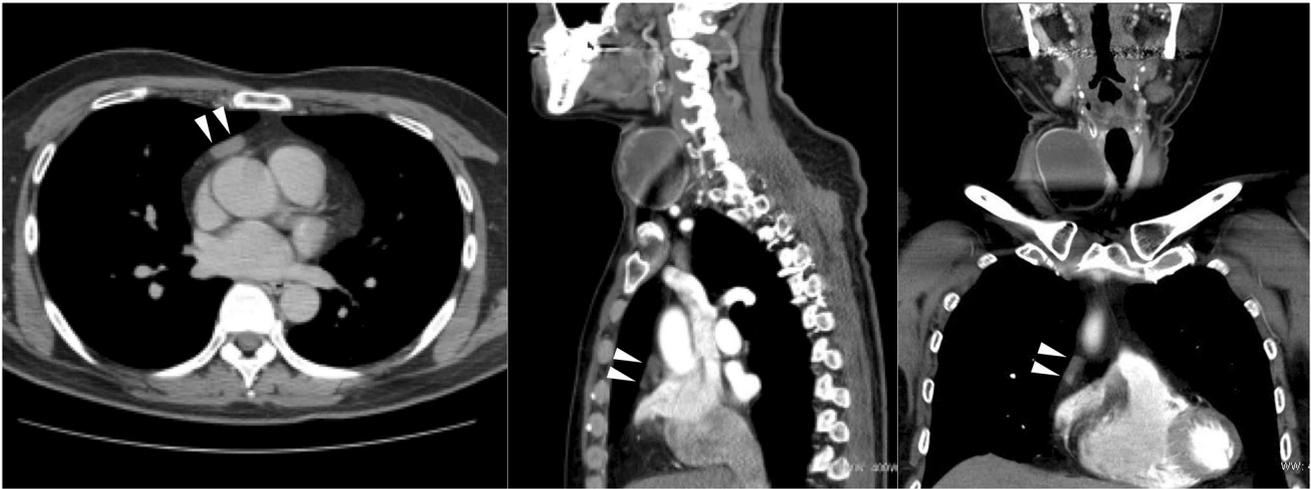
Chest CT revealed a mediastinal mass in front of the ascending aorta
